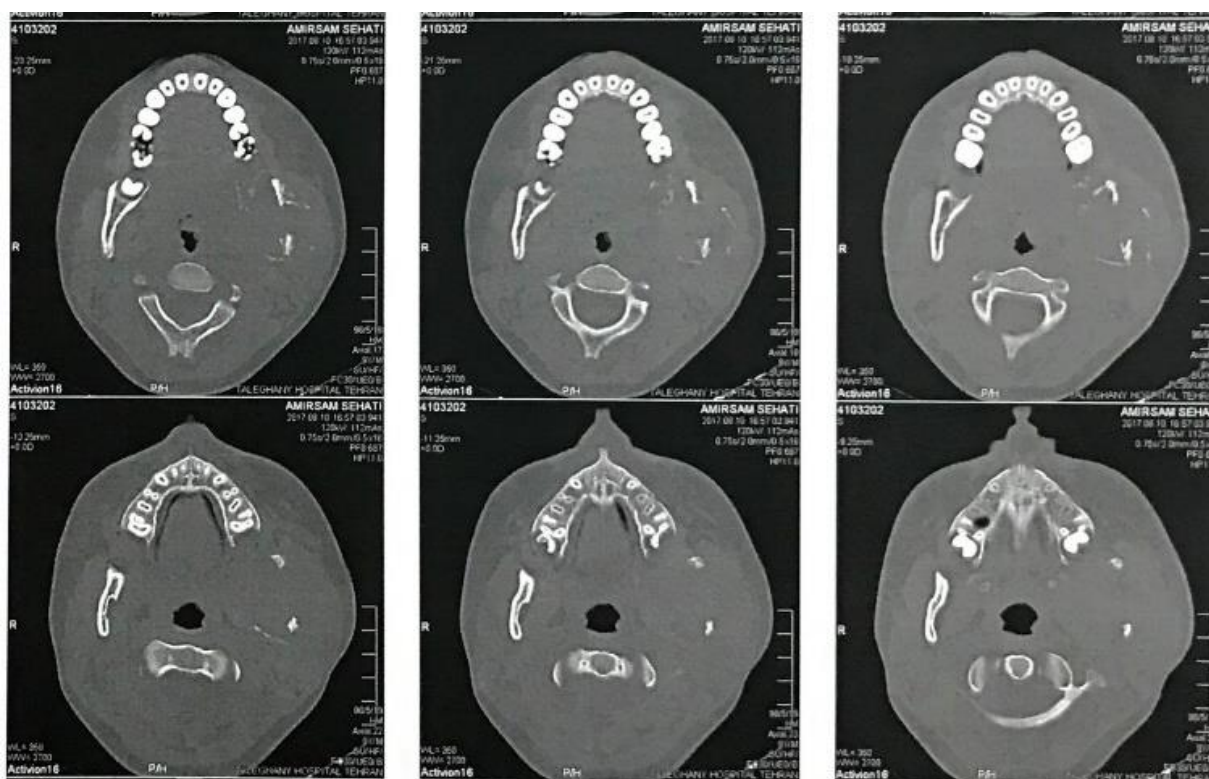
Computed tomography (CT) of patient
